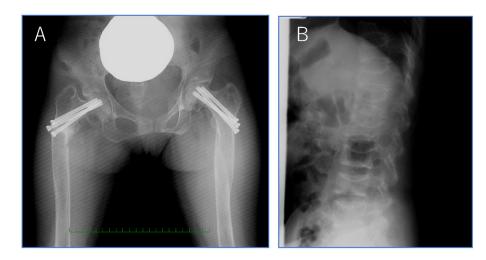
Plain radiographs of the patient before pregnancy. A) Posteroanterior view of the pelvis. B) Sagittal view of the spine. Bilateral femoral neck (A) and multiple previous vertebral compression fractures (B) are also shown.
